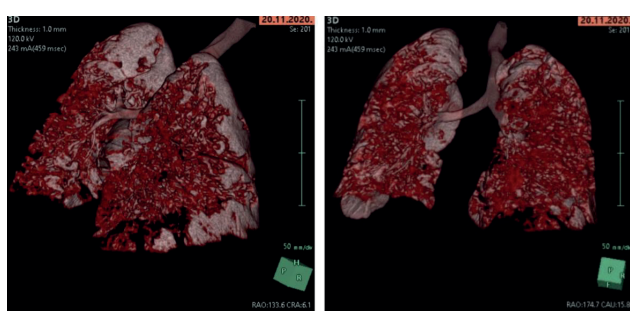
Chest CT of an index case
